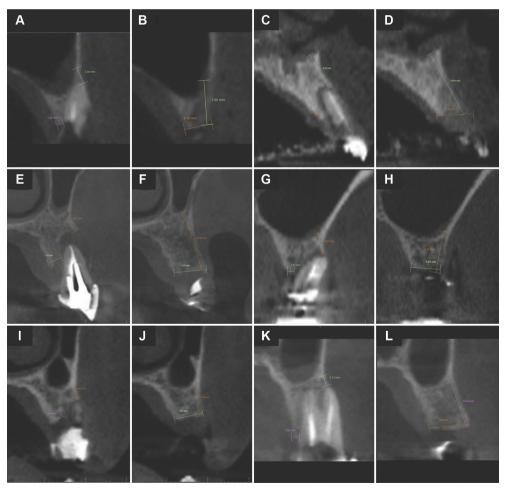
A: Initial CBCT of patient 7; B: Patient 7 CBCT sagittal image showing bone reconstruction with PDAR technique. C: Initial CBCT of patient 8; D: Patient 8 CBCT sagittal image showing bone reconstruction with PDAR technique. E: Initial CBCT of patient 9; F: Patient 9 CBCT sagittal image showing bone reconstruction with PDAR technique. G: Initial CBCT of patient 10; H: Patient 10 CBCT sagittal image showing bone reconstruction with PDAR technique. I: Initial CBCT of patient 11; J: Patient 11 CBCT sagittal image showing bone reconstruction with PDAR technique. K: Initial CBCT of patient 12; L: Patient 12 CBCT sagittal image showing bone reconstruction with PDAR technique.
